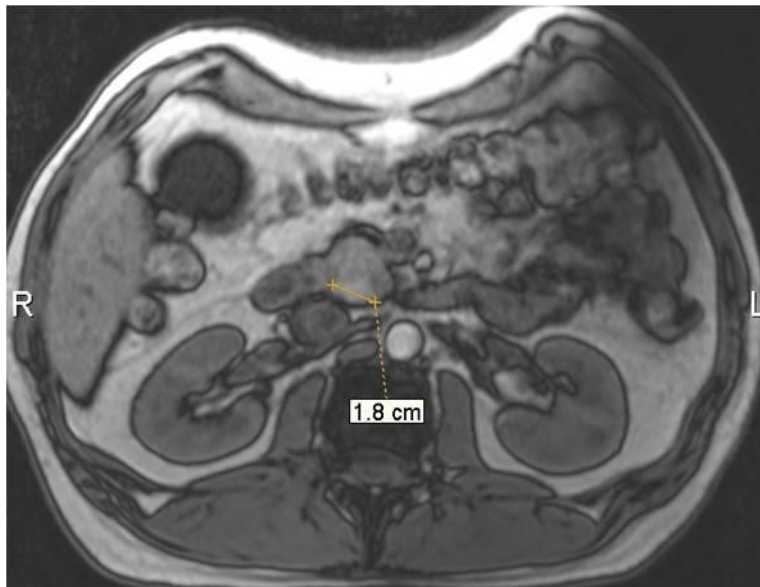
MRI of the patient K. August 24, 2016 MR-sequence T1VI, axial plane of scanning. Pseudocontrol in the head of the prostate of high intensity.
